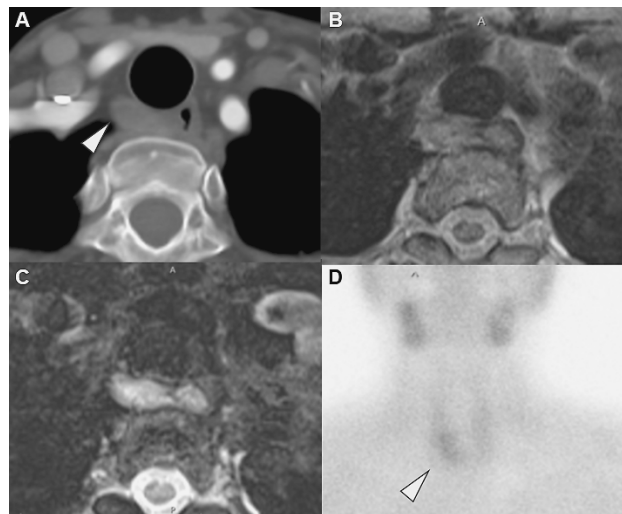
Preoperative images. A, Computed tomography (CT). A 20 × 10-mm mass is identified in the upper mediastinum, adjacent to the right esophageal wall (arrowhead); B, Magnetic resonance imaging (MRI) (T1-weighted image). B, Image reveals a cystic tumor with a high-intensity septum and a homogeneous low-intensity internal component; C, MRI (T2-weighted image). Image reveals a high-intensity septum and high-intensity tumor with internal heterogeneity; D, ^{99m}Tc-methoxyisobutylisonitrile scintigraphy. Radiotracer uptake is observed in the right upper mediastinum (arrowhead).
